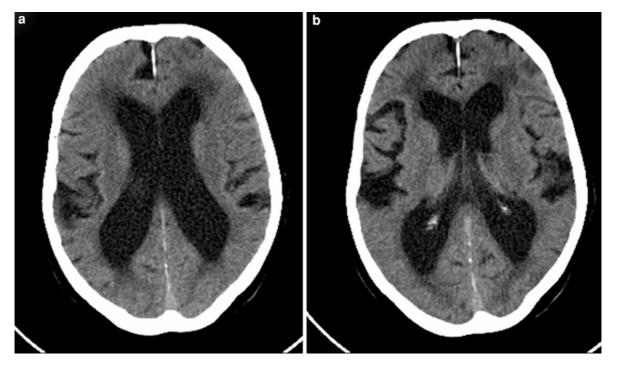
Follow-up brain CT study at low-dose (CTDI of 30.6 mGy) in a 79-year-old woman with (normal pressure) hydrocephalus. Low-dose axial CT images are of sufficient
